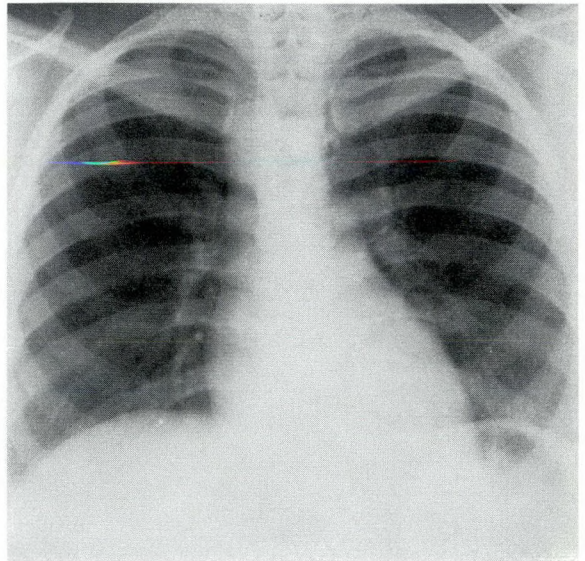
Routine posteroanterior radiograph of the chest showing normal lung fields. The heart is not enlarged. The aortic knob is absent on the left and there is evidence of an aortic knob or arch projecting to the right at the level of the fourth and fifth thoracic segments.
